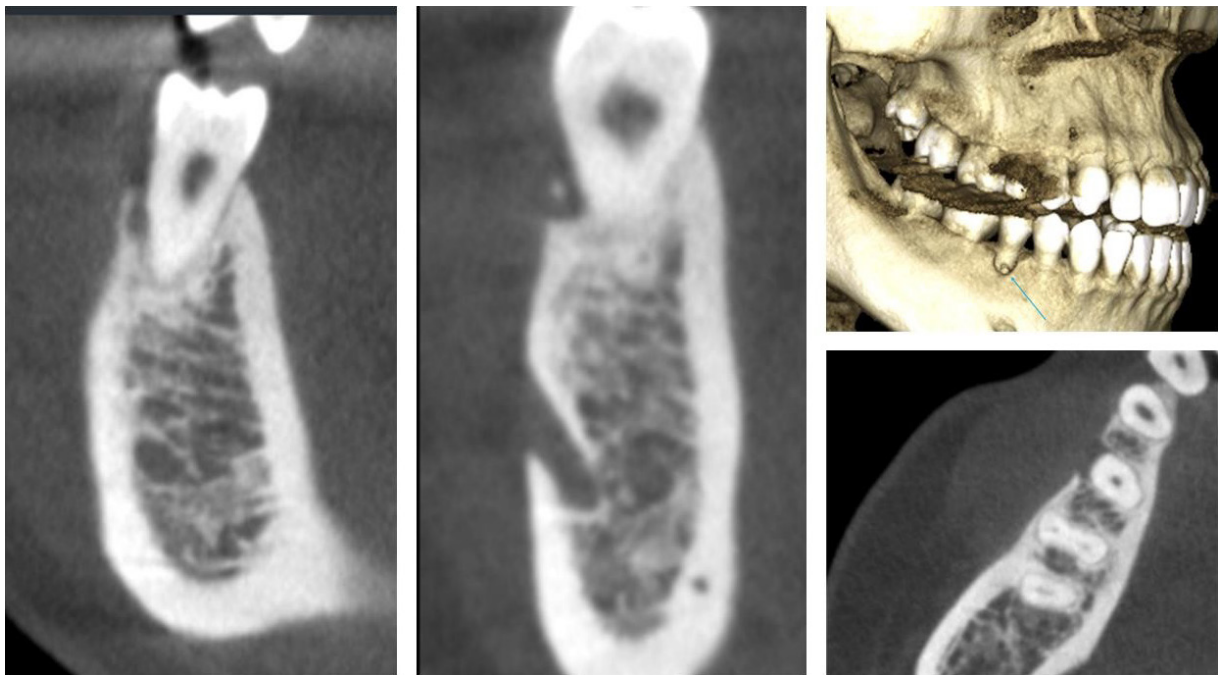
Detection of a foreign body associated with the region of interest based on CBCT evaluation.
